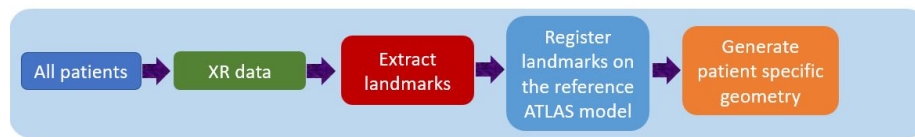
The steps of generating patient specific geometry using X-ray data (repeat several times).
